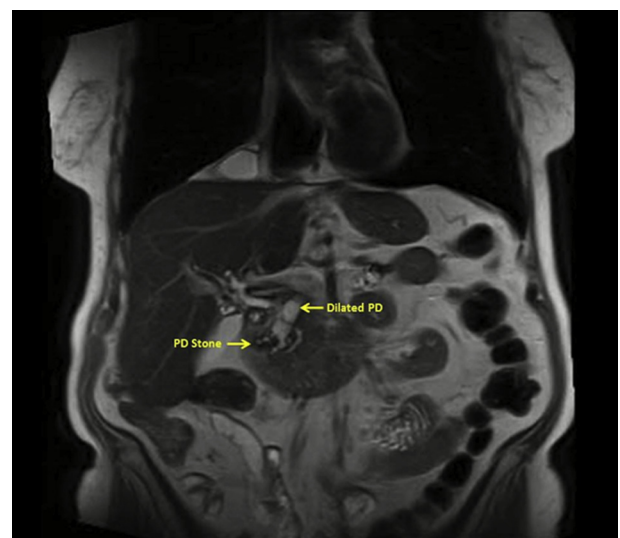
Magnetic resonance imaging with MRCP revealed pancreas divisum with a very dilated pancreatic duct and a large pancreatic duct stone impacted at the minor papilla.
